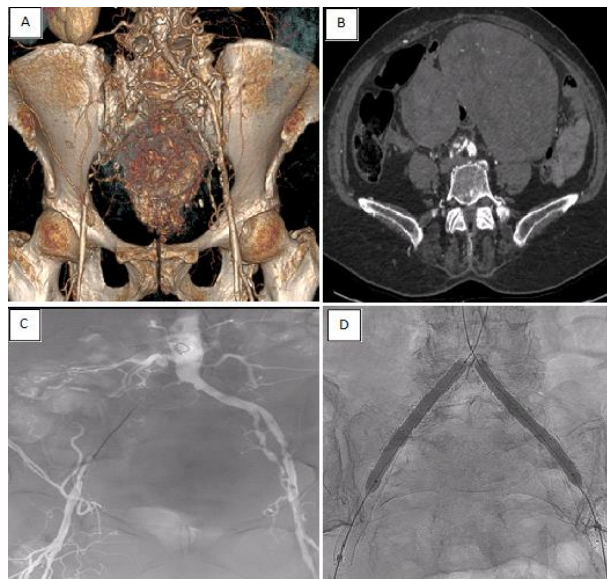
(A): CTA showed complete occlusion of the right common and external iliac arteries and severe stenosis on the left side. (B): There was also evidence of incidental abdominal and pelvic mass with left ovary origin, later confirmed as a Brenner tumor. (C and D): The patient underwent bilateral common and external iliac artery balloon-expandable stents (kissing technique).
